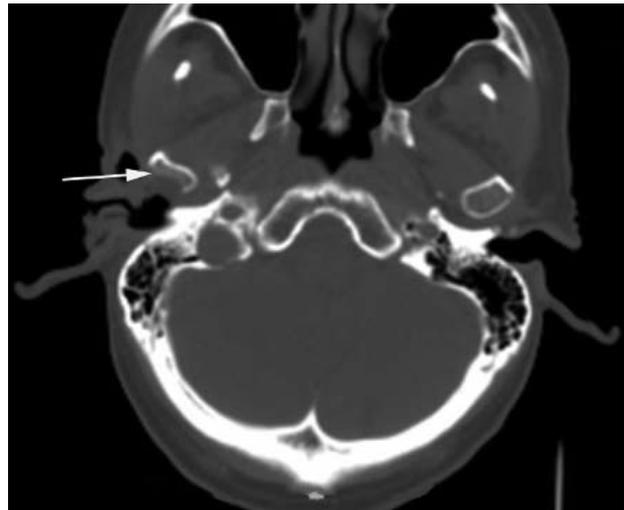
Axial computed tomographic scan obtained seven months after treatment of squamous cell carcinoma of the right parotid gland in the patient in case 2 shows erosion of the posterior aspect of the right mandibular condyle (arrow). This area of erosion corresponded to an area of increased fluorodeoxyglucose uptake and was suggestive of cancer recurrence.
